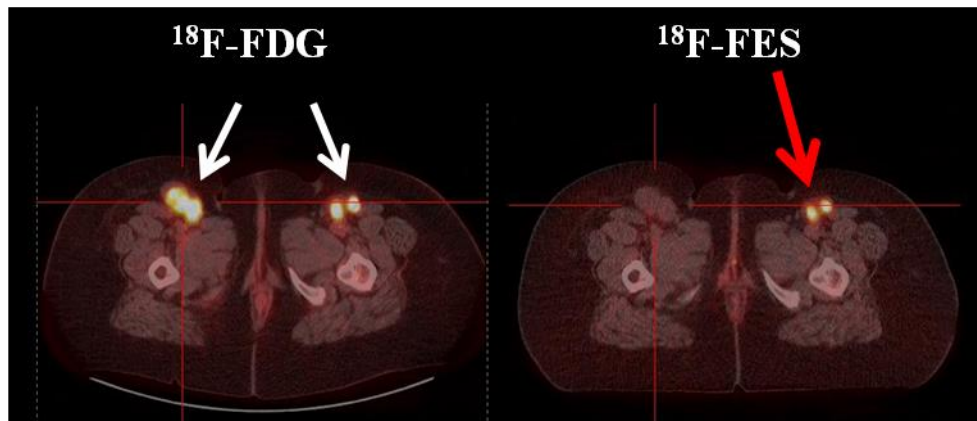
A PET/CT fused image of ^{18}F -FDG uptake (left) and ^{18}F -FES uptake (right). Uptake of ^{18}F -FDG indicates presence of multiple tumour nodes. On the other hand, the uptake of ^{18}F -FES identifies a difference in estrogen receptor expression in the nodes. Figure courtesy of F. Bénard.
